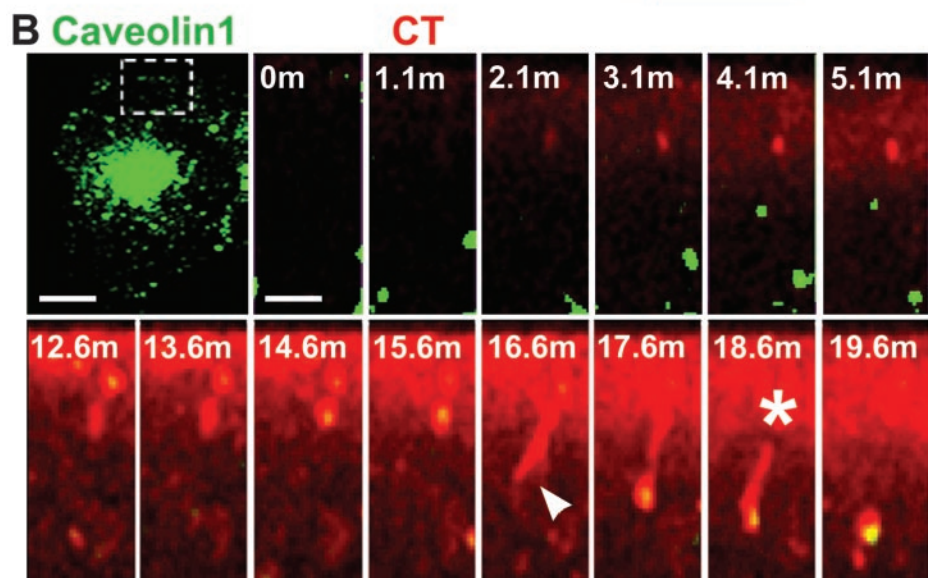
Clathrin and caveolin-dependent pathways mediate CT internalization. (A) BSC1 cells stably expressing EYFP-LCA cells were incubated with 20 nM CT(E112D) for 30 min at 37°C, washed, and processed for time-lapse recording. A clathrin-coated pit-like structure, selected from the dorsal cell surface (image 1, stippled-line box, and enlarged in images 2 and 3), containing CT was analyzed with the aid of a kymograph plot for clathrin and toxin content over time (images 4–6). (B) CT(E112D) was added during the time-lapse acquisition to BSC1 cells transiently expressing Cav1-EGFP. The time-lapse series (stippled-line box) shows entry of CT into a caveolin 1-containing tubulo-vesicular structure (Movie 7, a and b). The initial short tubular invagination stretches and eventually disconnects from the cell surface. Bars, 20 μm (whole cell) and 5 and 3 μm (cropped regions).
